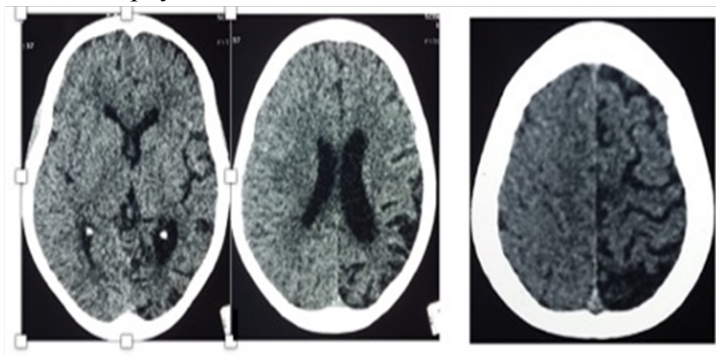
Non-injection brain CT scan showing left cerebral hemiatrophy and LV dilatation witnessing caudate nucleus head's atrophy.
